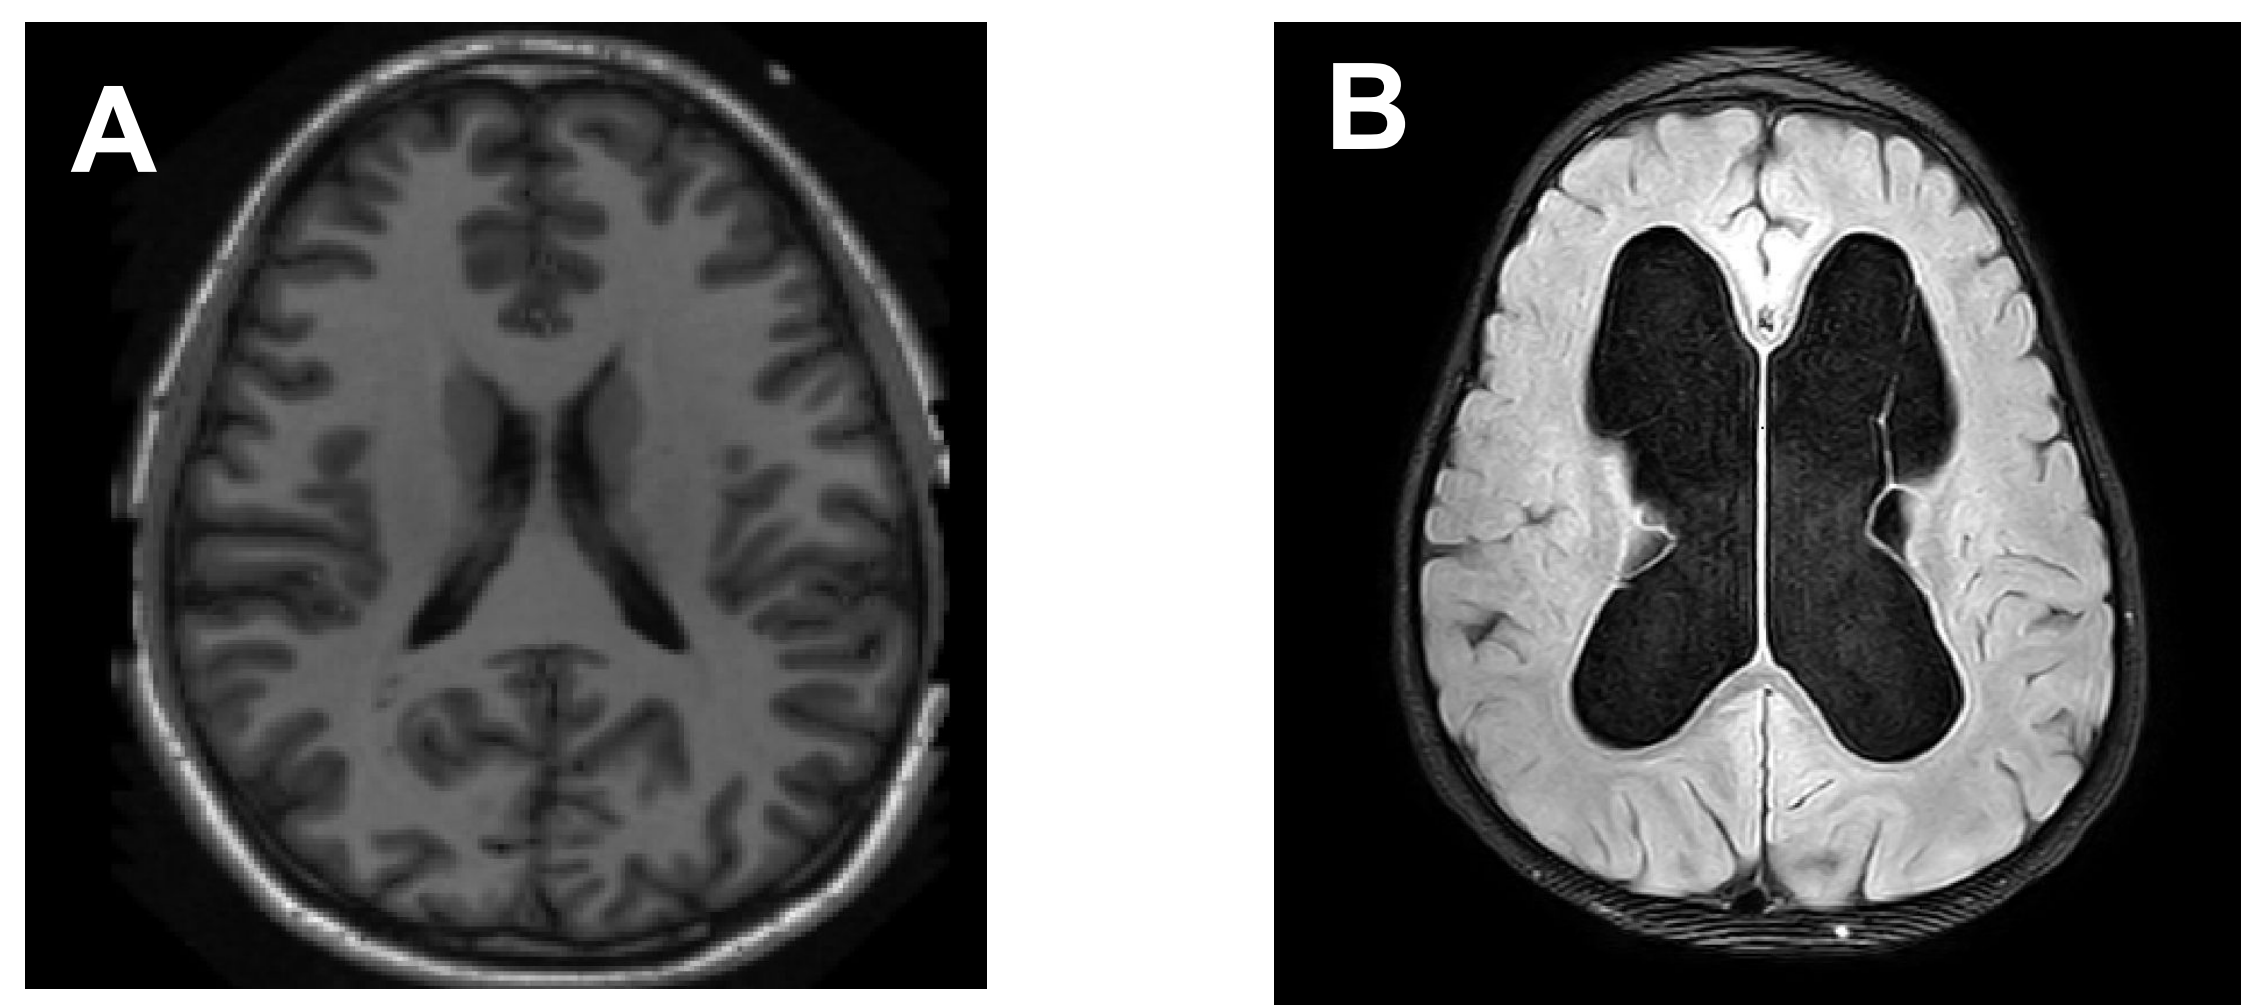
MRI images of the lateral ventricles for a patient without hydrocephalus (A) and with hydrocephalus (B).
